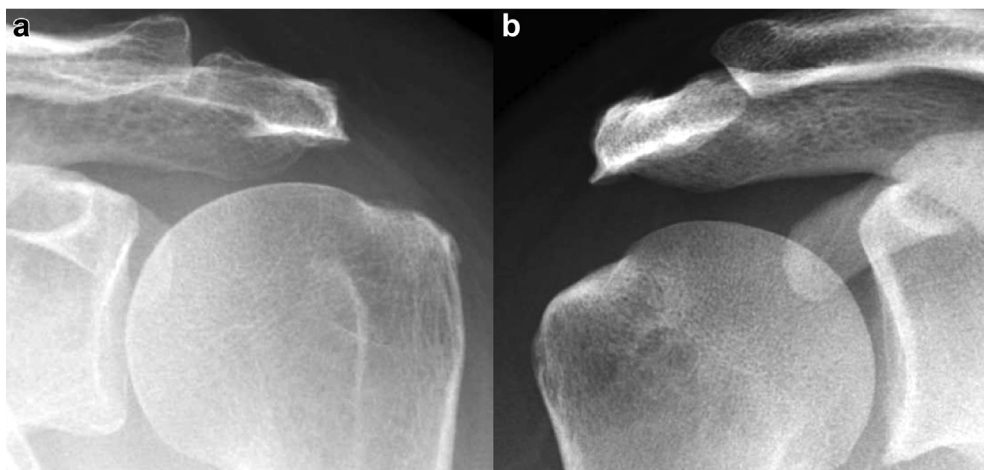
Radiograph showing SLAM signs also identified as (a) hat-shaped spur in association with bursal-sided tear and (b) lateral traction spur in association with full-thickness tear. SLAM, sharpened lateral acromial morphology.
